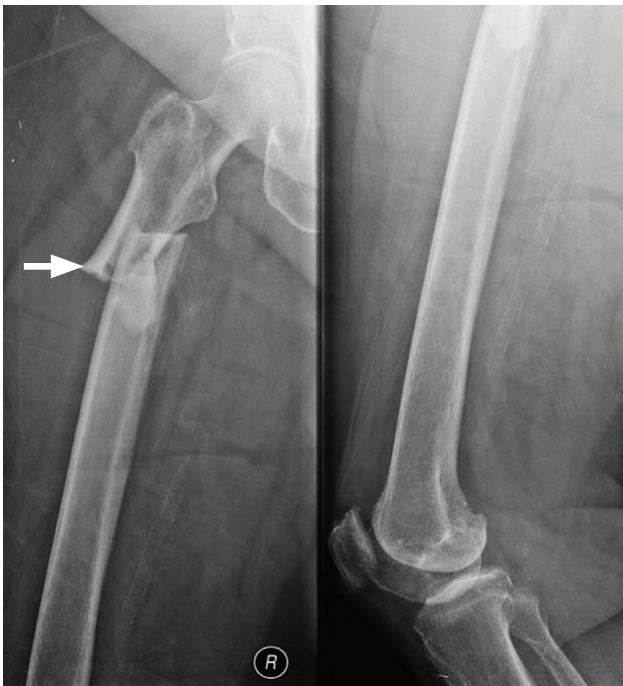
Radiograph of right femoral fracture, the second fracture of the patient, showing transverse fracture of the proximal femoral shaft. Also shown is the "beaking" (arrow) of lateral cortex at the fracture site as well as cortical thickening.
